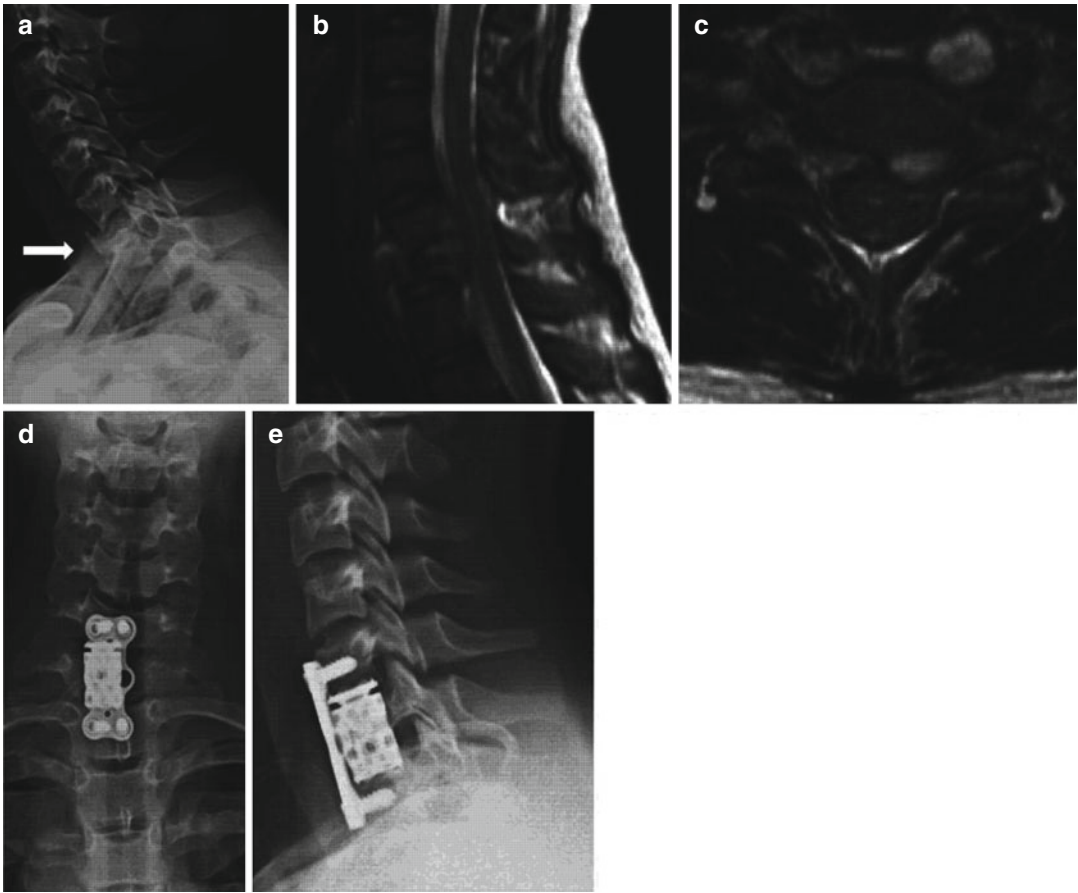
A 10 year old child presented with C7 tuberculosis and quadriplegia. (a) Lateral radiograph shows collapse of C7 vertebra with widened prevertebral shadow (white arrow). (b, c) Sagittal and axial MR images show vertebral destruction, perivertebral abscess formation
